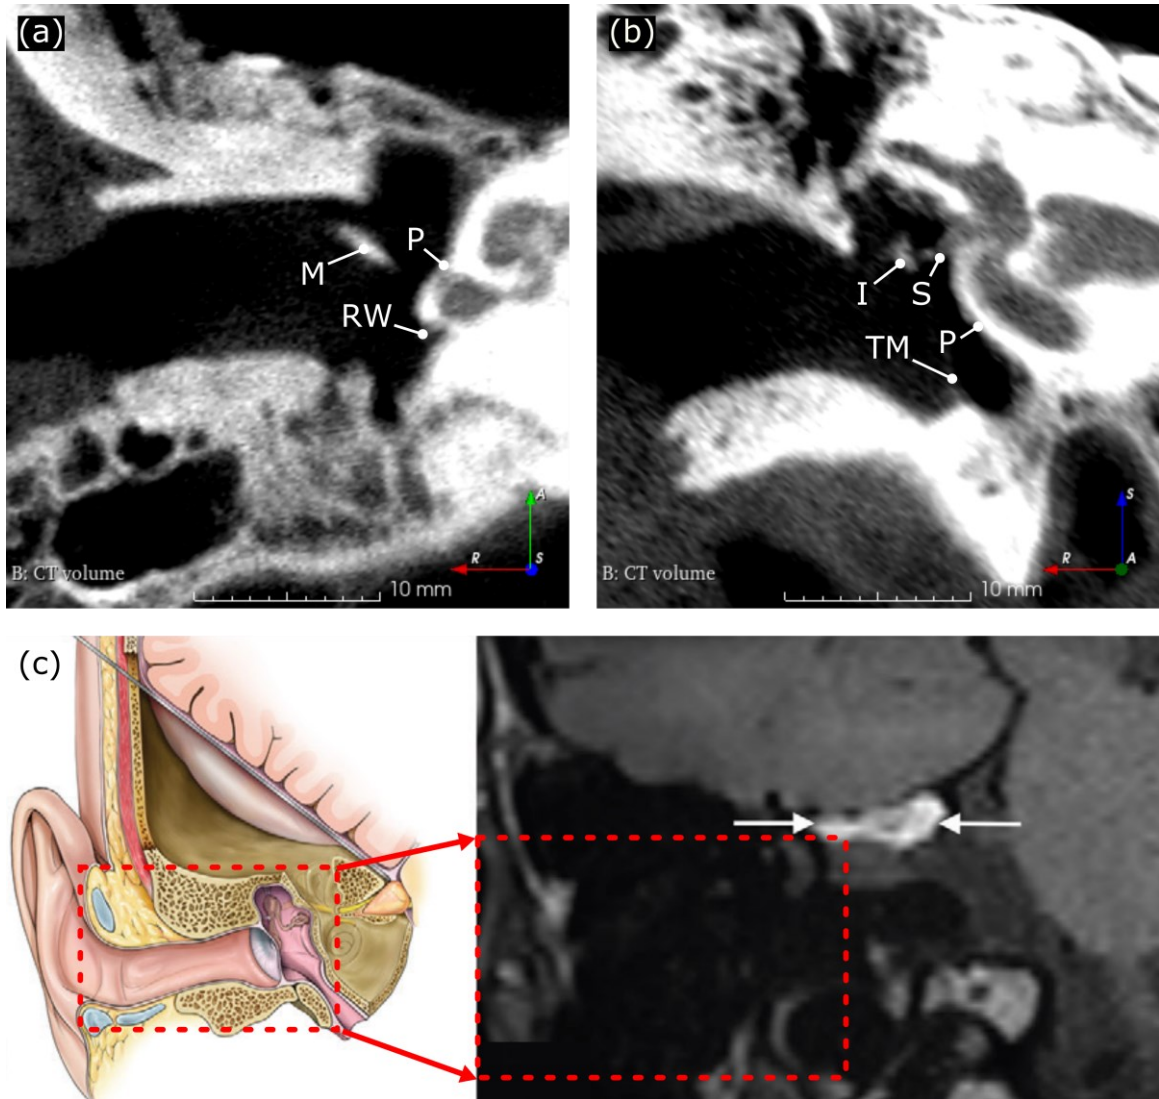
Radiological images of the middle ear. (a) and (b) axial and coronal computed tomography (CT) images of the human middle ear. (c) Magnetic resonance (MR) coronal image of the human middle ear outlined by the dotted red box. White arrows highlight a graft of fat tissues laid along the roof of the inner auditory canal. Derived from Ref. [55]. M, malleus; P, promontory; RW, round window; I, incus; S, stapes; TM, tympanic membrane.
